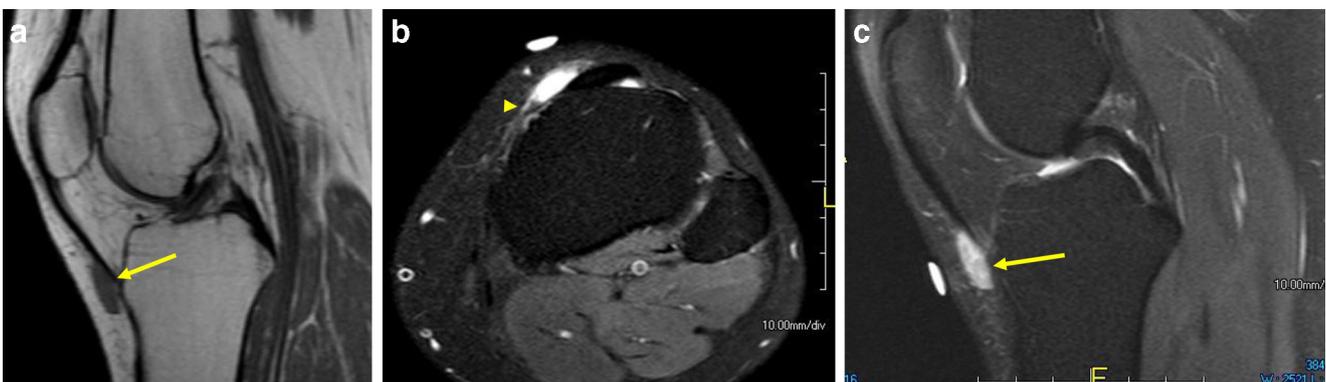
A 24-year-old woman with a non-tender palpable subcutaneous knee mass. a Sagittal T1-weighted MRI shows a 1.5-cm hypointense nodule superficial to the patellar tendon (*arrow*). b Axial proton density-weighted MRI obtained 4 years later shows essentially no growth, with mild peritumoral soft tissue edema (*arrowhead*) extending
